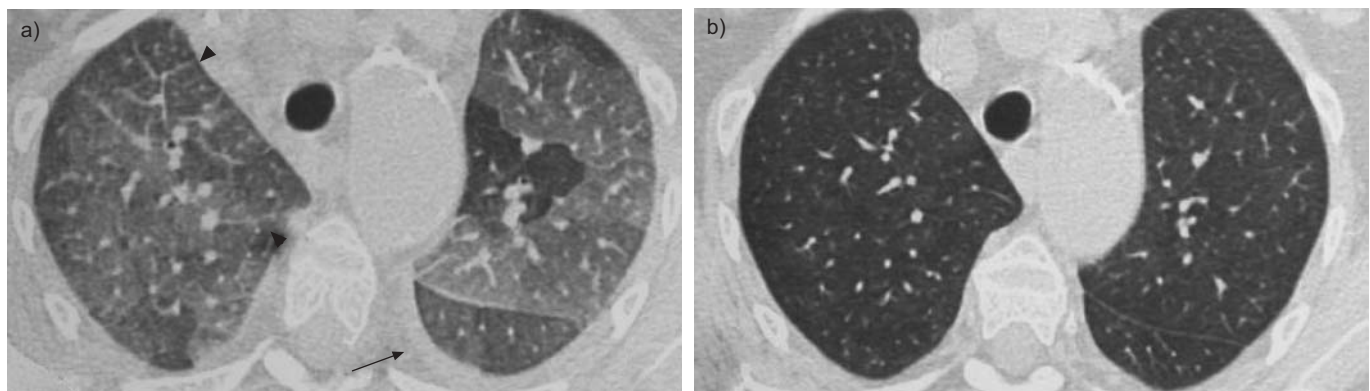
a) Cross-sectional high-resolution computed tomography (HRCT) demonstrating mosaic-type, ground-glass opacity of both lungs, which is associated with interlobular septal thickening (arrowheads). The arrow indicates the presence of a small pleural effusion bilaterally. The central pulmonary veins and left atrium are normal (not shown). The findings are highly suggestive of pulmonary veno-occlusive disease. b) An HRCT image obtained at the same level as in a) following treatment with *i.v.* defibrotide, which shows complete resolution of ground-glass opacities, thickened interlobular septa and pleural effusion.
